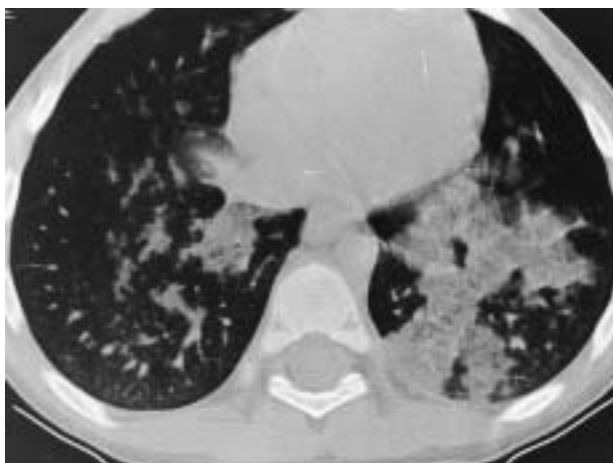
a) Chest radiograph showing diffuse parenchymal consolidation of the left lower lobe and patchy infiltrates in the right upper lobe. b) Computed tomography scan showing bilateral alveolar consolidation, interlobular septal thickening and lymphatic infiltration.
